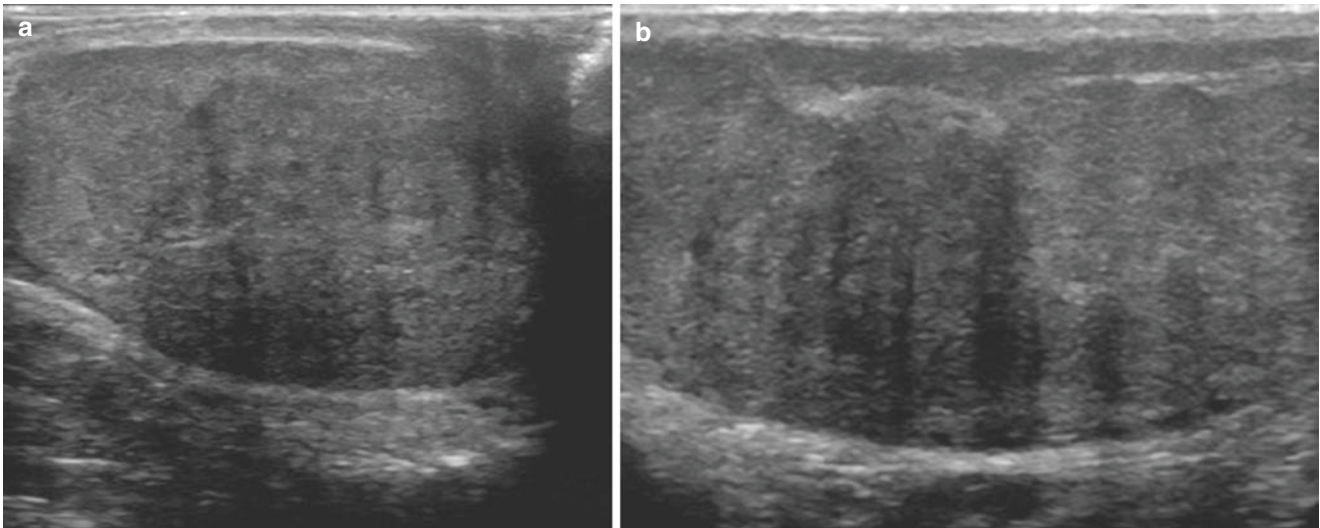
Testicular adrenal rest tumors. Ultrasound of both testicles with ill-defined bilateral intratesticular hypoechoic lobulated masses surrounding the mediastinal testis (*white arrows*)
